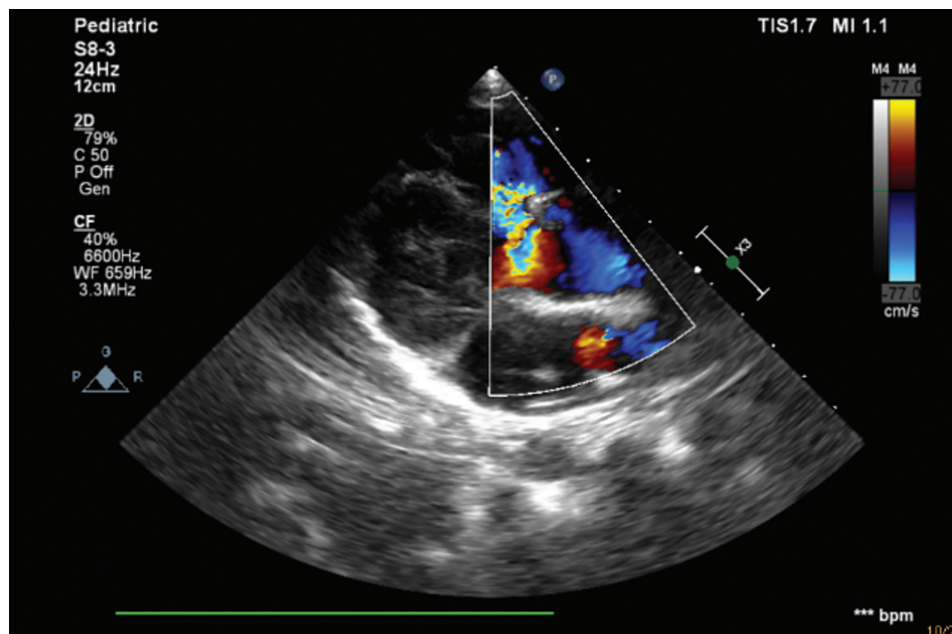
Transthoracic echocardiography with Doppler mode showing tricuspid valve regurgitation
